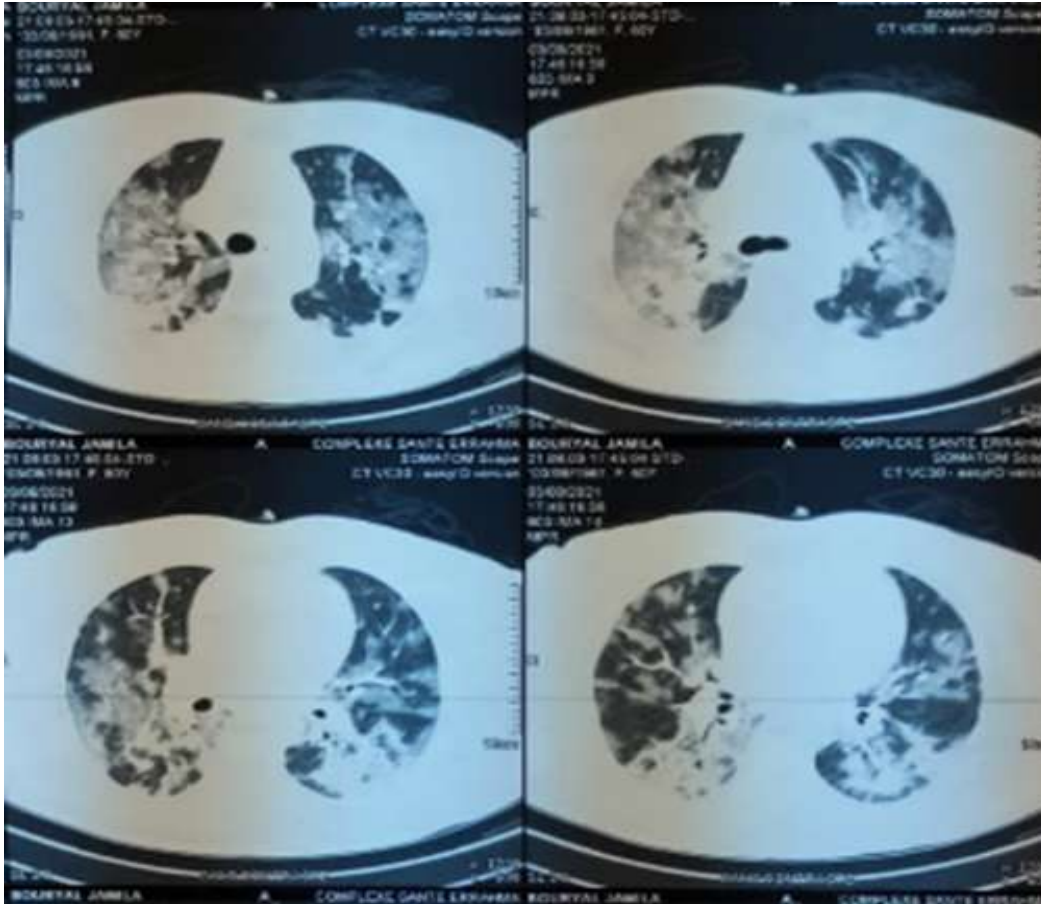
Chest CT on admission.
